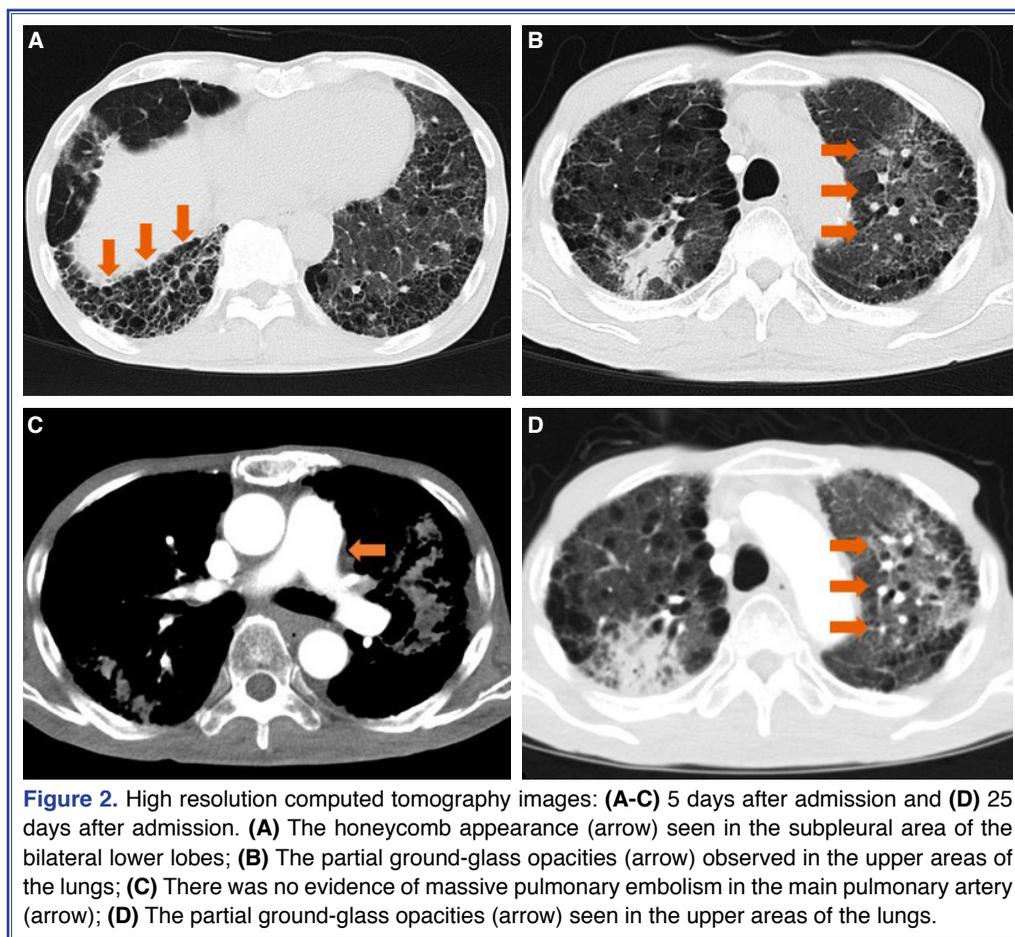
High resolution computed tomography images: (A-C) 5 days after admission and (D) 25 days after admission. (A) The honeycomb appearance (arrow) seen in the subpleural area of the bilateral lower lobes; (B) The partial ground-glass opacities (arrow) observed in the upper areas of the lungs; (C) There was no evidence of massive pulmonary embolism in the main pulmonary artery (arrow); (D) The partial ground-glass opacities (arrow) seen in the upper areas of the lungs.
